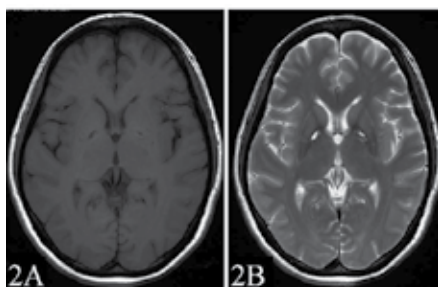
Magnetic resonance imaging in the delayed stage of carbon monoxide intoxication.
